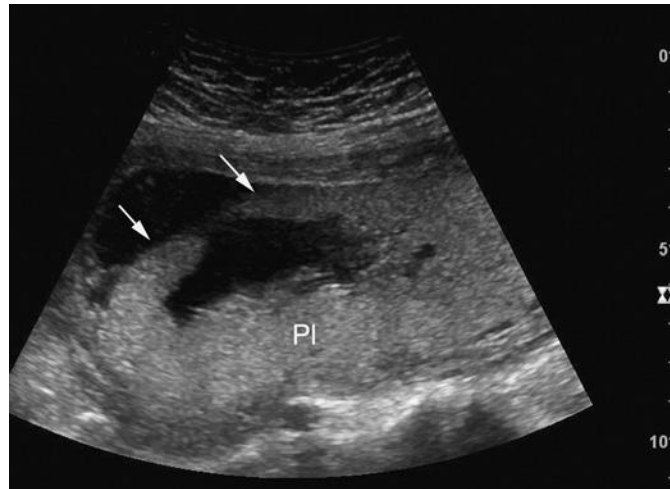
Sonogram of a gravid uterus in the second trimester demonstrating a circumvallate placenta (PI). The infolding of the edge of the placenta (*arrows*) should not be confused with a uterine synechia.
